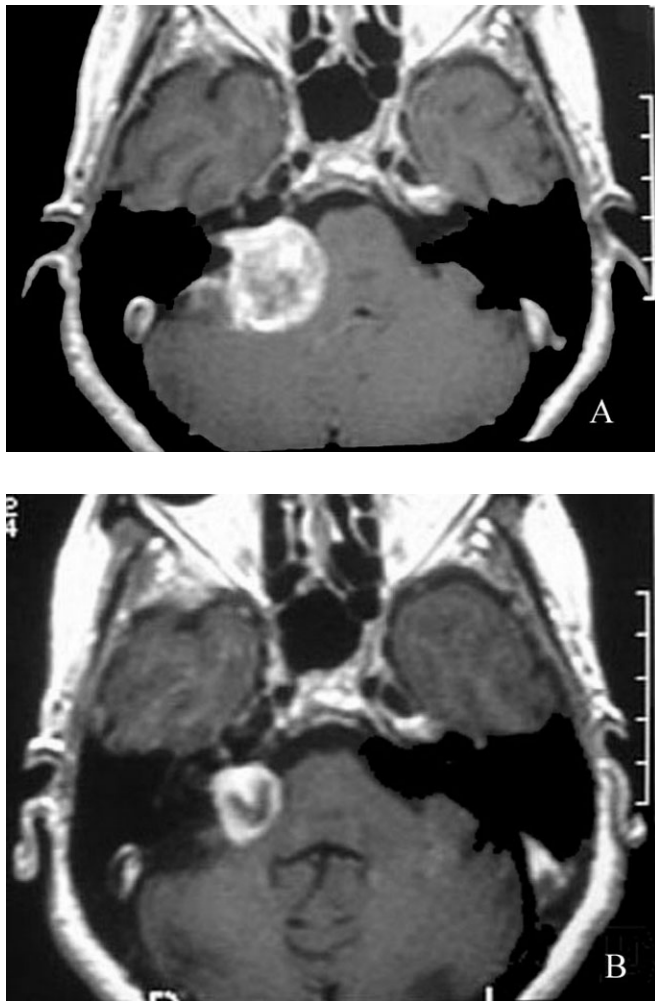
Axial MRI slices of an acoustic tumor [A] before, and [B] 2 years after radiosurgery. The patient had a 50% speech discrimination rate on the affected side before treatment, which rose to 80% at the time of the follow-up study.
